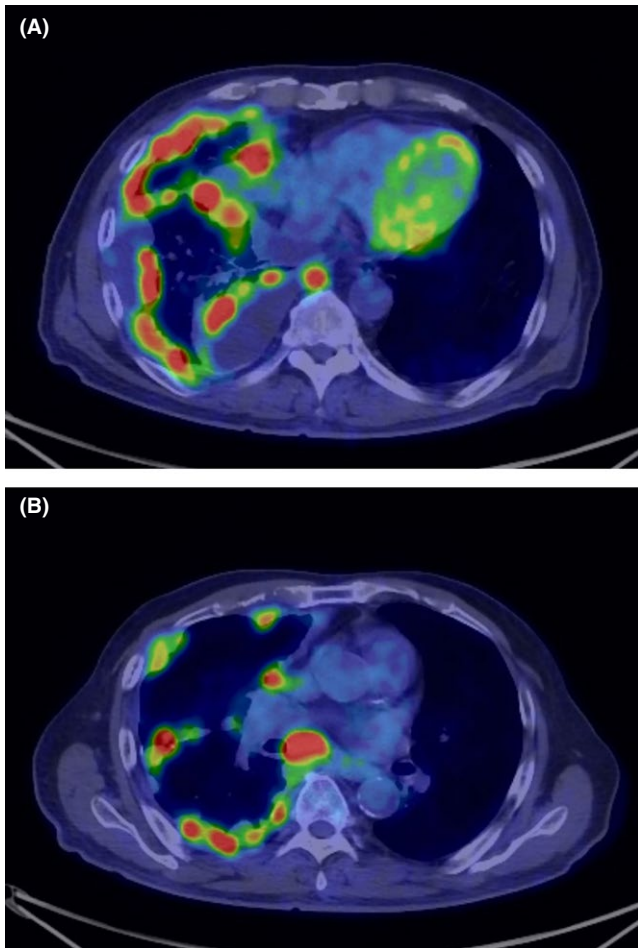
Positron emission tomography/computed tomography findings. Positron emission tomography/computed tomography revealed fluorodeoxyglucose accumulation in many pleural lesions (A) and enlarged mediastinal lymph nodes (B)
